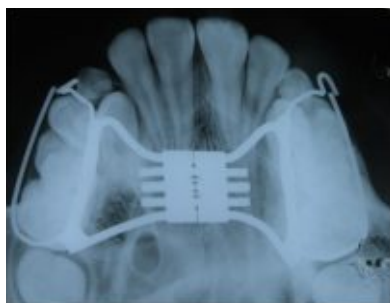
occlusal radiograph after placement of rapid maxillary expander
